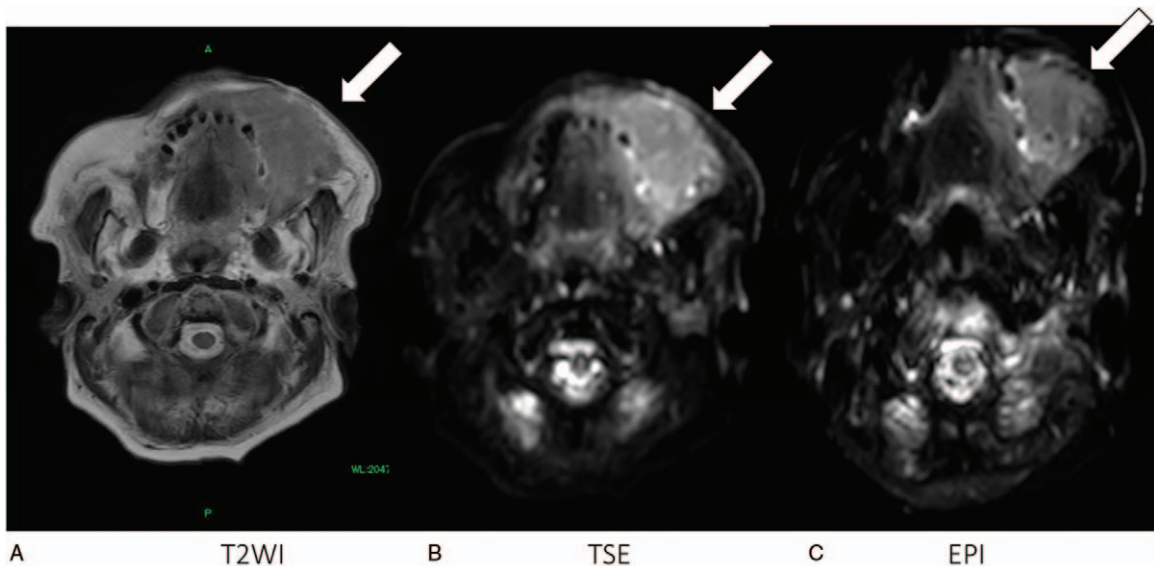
MRI images (A: T2WI image, B: TSE-DWI image, C: EPI-DWI) of a 91-year-old woman with gingival cancer. A tumor of TSE-DWI image (arrows) is more similar to T2WI image than EPI-DWI image.
